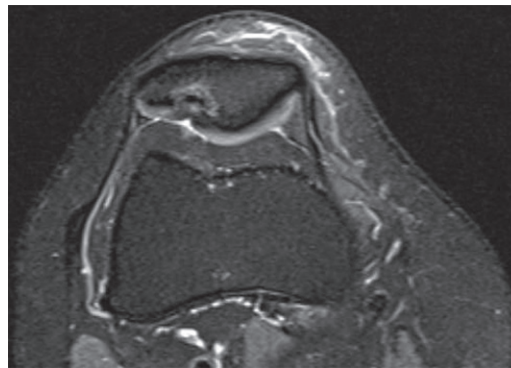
Dorsal defect of the patella in a 27-year-old man with knee pain after trauma. Axial T2-weighted fat-suppressed MR image shows a subchondral defect with irregular but largely intact overlying cartilage. Note that the anterior patellar cortex is not affected.
